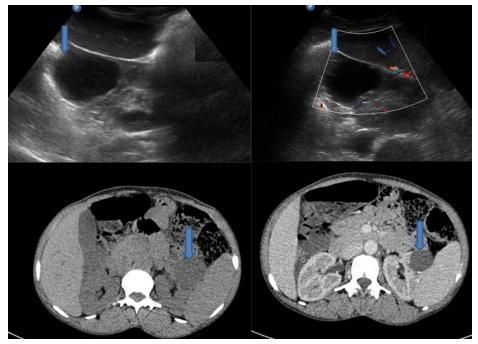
Simple Cyst: well-defined thin walled anechoic lesion involving upper pole of left kidney. Color Doppler showing no internal vascularity. NECT and CECT images showing non-enhancing thin walled fluid density lesion in left kidney
